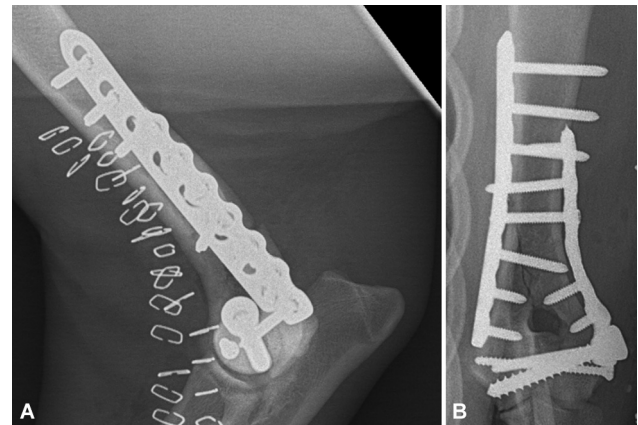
Mediolateral and craniocaudal postoperative radiographs of case 4. (A, B) show the addition of a 2.4-mm transcondylar screw placed distocranially to the primary transcondylar screw.
